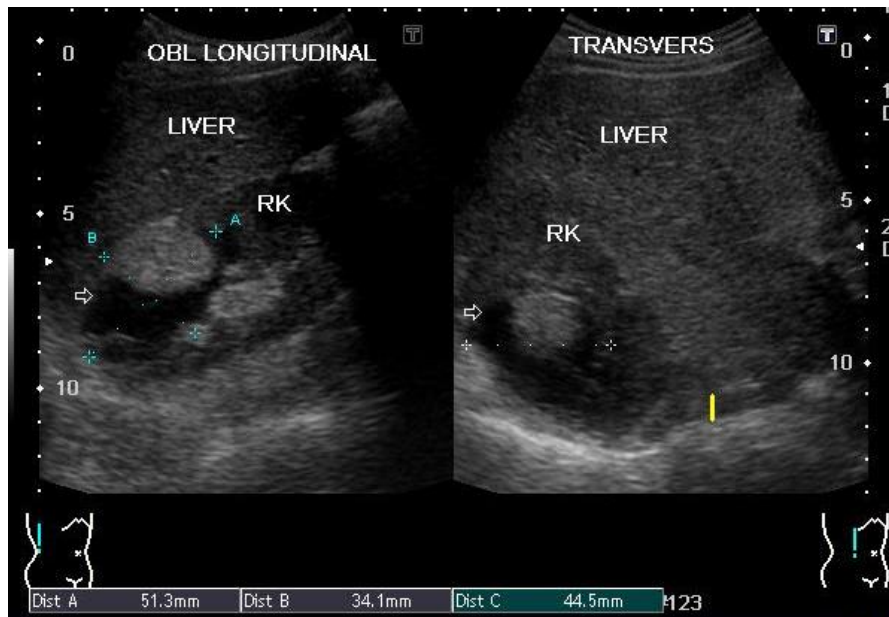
Ultrasound image depicting cystic mass in the upper pole of the right kidney with hyperechogenic fat overlaying the cystic component.
